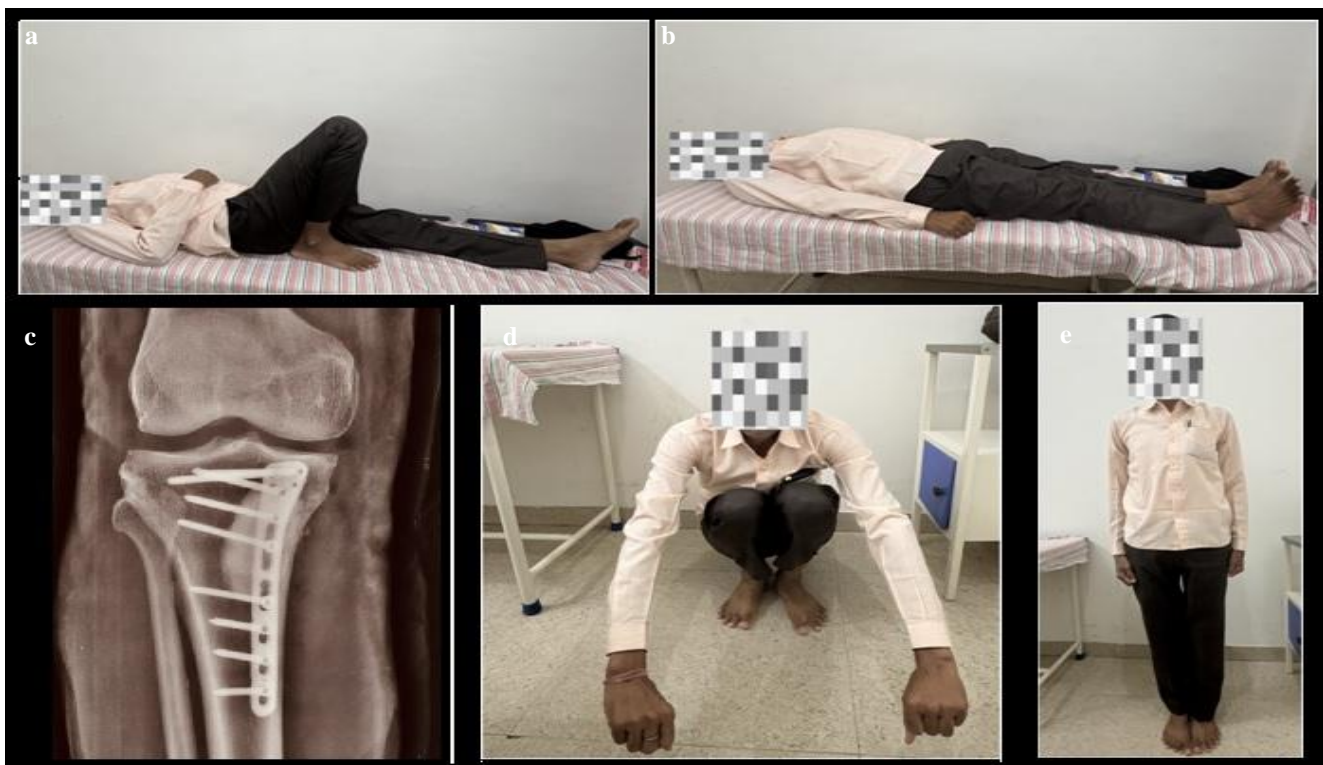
(a-e): Follow-up radiograph and clinical images at 3 months demonstrating maintained alignment, stable fixation, independent mobility, and a full pain-free functional range of motion, reflecting excellent clinical recovery.
